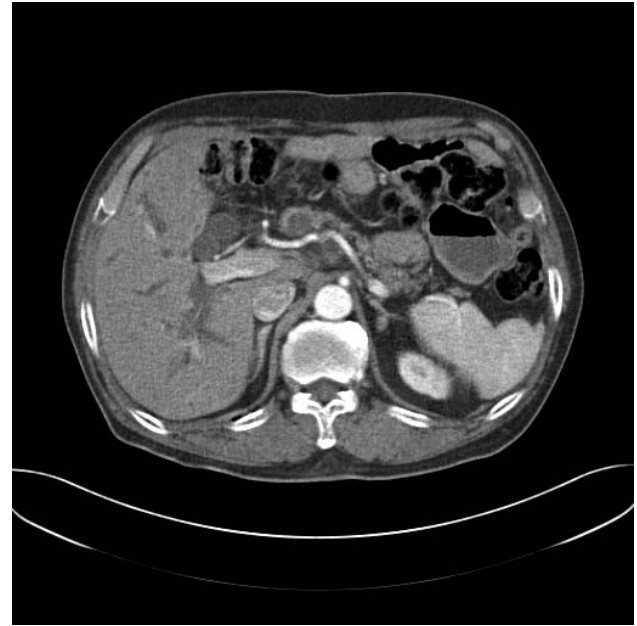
Abdominal CT scans of Case 2. There is high attenuation lesion on the precontrast scan in the intraluminal portion of the CBD, with abrupt luminal narrowing of the distal CBD. There is no definite wall thickening of the bile ducts. Pancreas shows an 1.3-cm low-attenuation lesion in head portion with mild dilatation.
